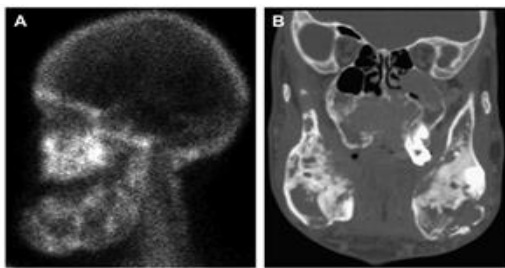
(A, B) Polyostotic fibrous dysplasia. An aberrant growth of the mandibular condyles, rami, and body, along with areas of sclerosis and cystic lucency associated with fibrous dysplasia, are seen on a coronal CT scan performed at the mandibular level. An abnormal thickening, expansion, and uptake in the mandible is shown by a bone scan. [16]
